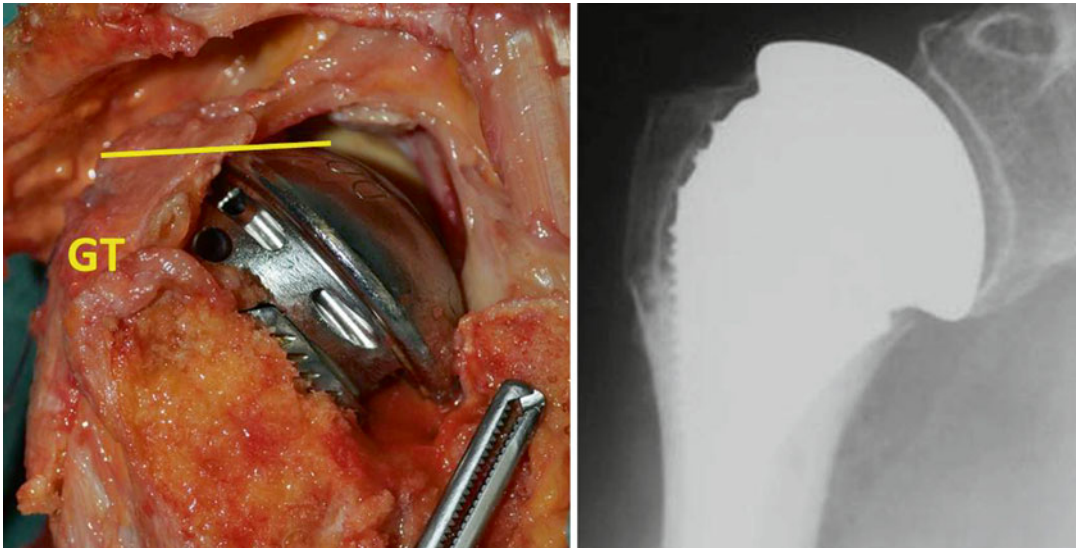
Left: yellow line refers to level of gt and contact with the implant (GT). Right: post-op X-ray control demonstrating the perfect restoration of the anatomy*
